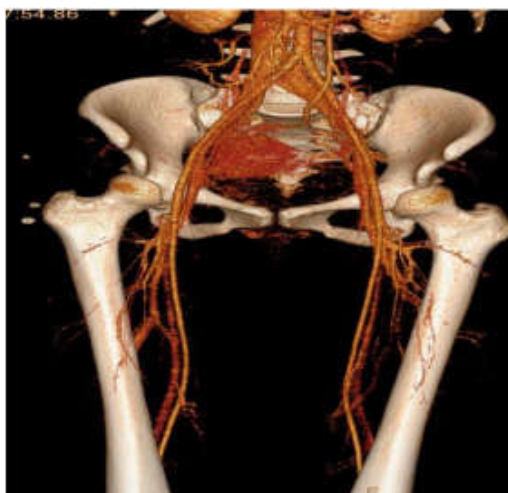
CT Peripheral Angiogram.
